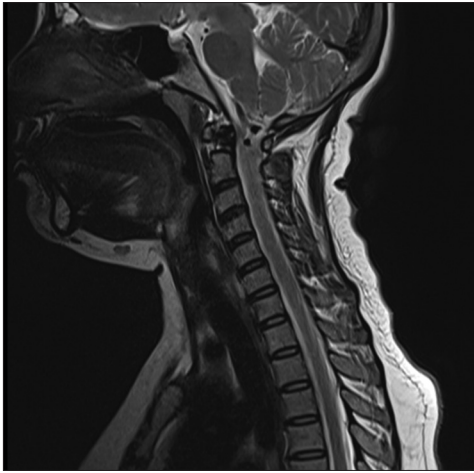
Sagittal MRI, T2 image showing CVJ compression by both vertebral arteries
